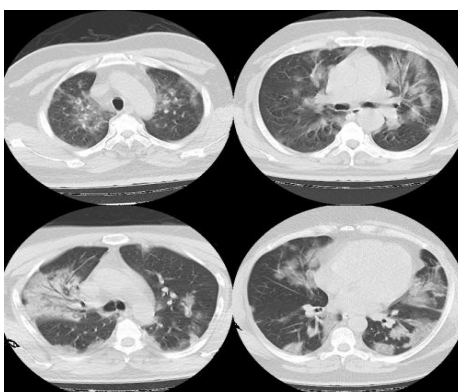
Moderate lung involvement image on CT
